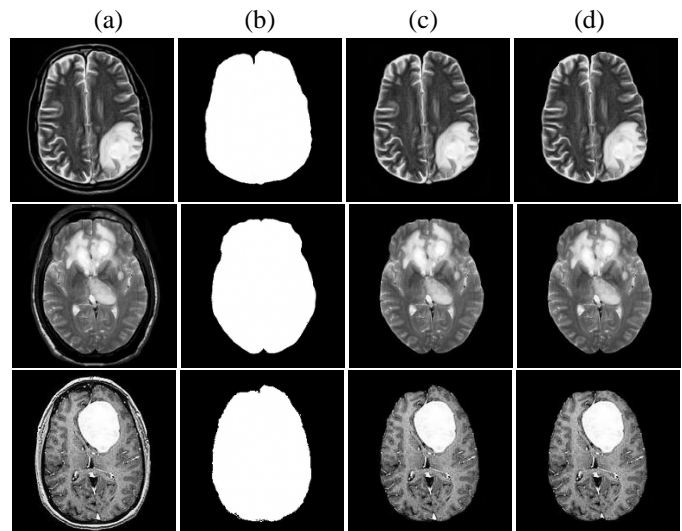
Skull stripped abnormal brain MR images: a) Input brain MRI, b) Brain mask, c) Skull stripped MR image by proposed method and d) Skull stripped by BSE
